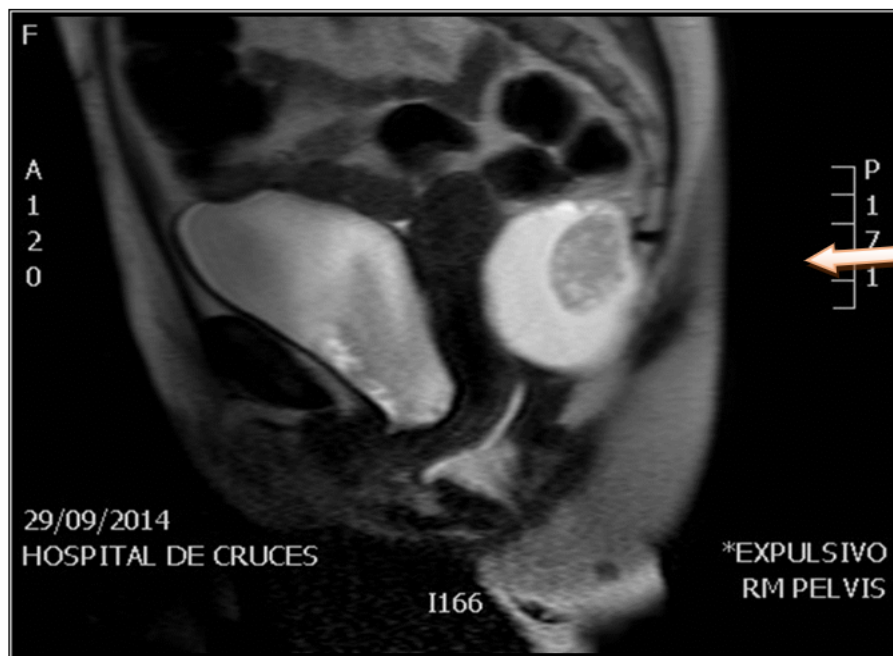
MRI Pelvic sagittal view, showed well delimited, retrorectal and multi-partitioned complex cyst.
